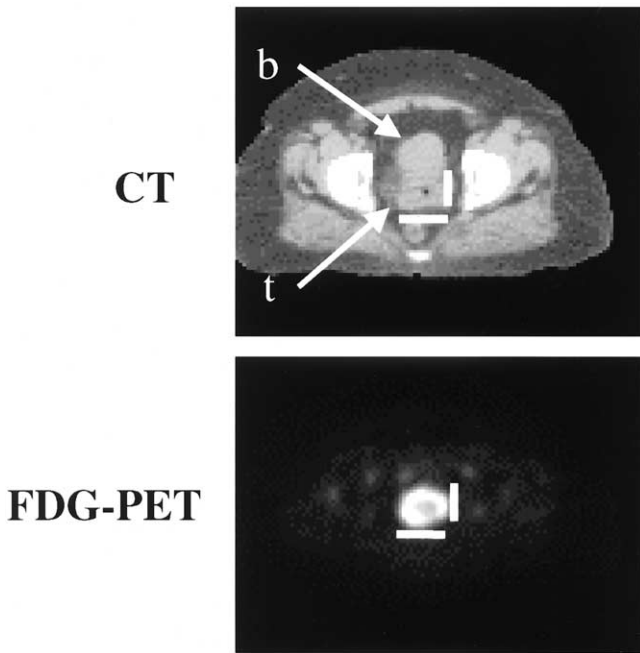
Selected transaxial slices from a representative CT and PET study are shown. The primary tumor (t) and bladder (b) are identified on the CT, and the anteroposterior and lateral dimensions are indicated by bars.
